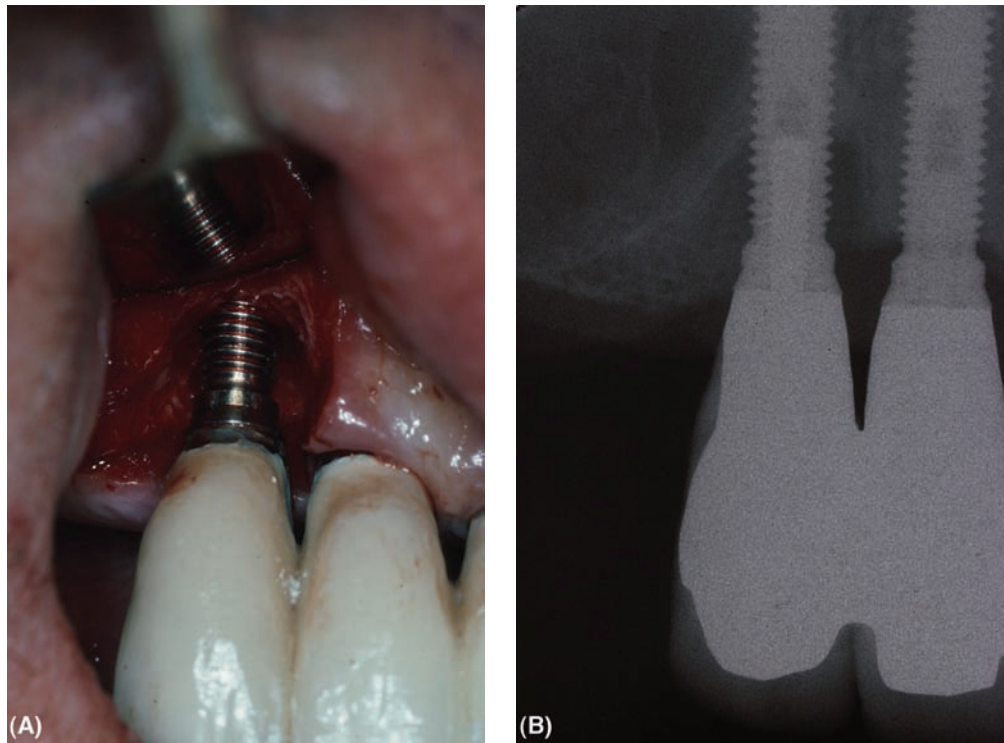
(A) A clinical photograph of a surgically exposed implant that has suffered from peri-implantitis. The inflammatory tissue has been removed to reveal bone loss that forms a circumferential gutter. (B) A radiograph of the lesion showing the wide saucerized pattern of bone loss, typical of peri-implantitis.
